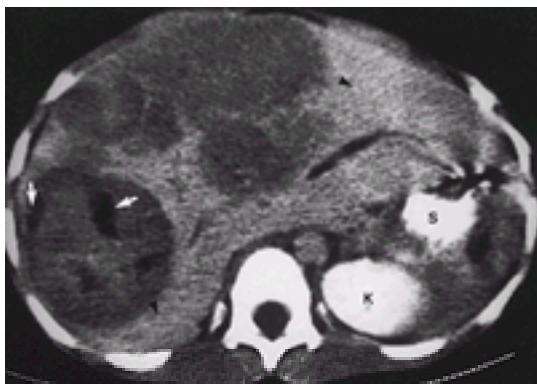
Hepatocellular carcinoma. Computed tomographic (CT) section of the abdomen with contrast medium enhancement shows multiple area of nonuniform lower density than the adjacent normal liver occupying most of the liver. The area of more lower density is representative of focal necrosis (*arrows*). Only small part of the left lobe and right lobe of the liver is normal (*arrowhead*). *K*, kidney; *S*, stomach
